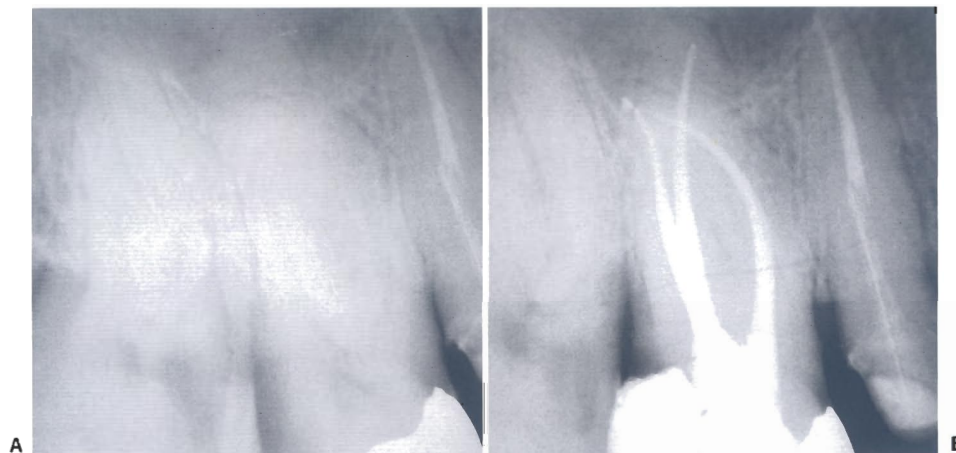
Clinical cases of teeth with curved canals. ProTaper S1 and S2 were used to shape the coronal third of the canal and the instruments of the ProSystem GT Series to shape the apical one third. A. Preoperative radiograph of the upper right first molar. B. Postoperative radiograph (E. Berutti) (continued).
